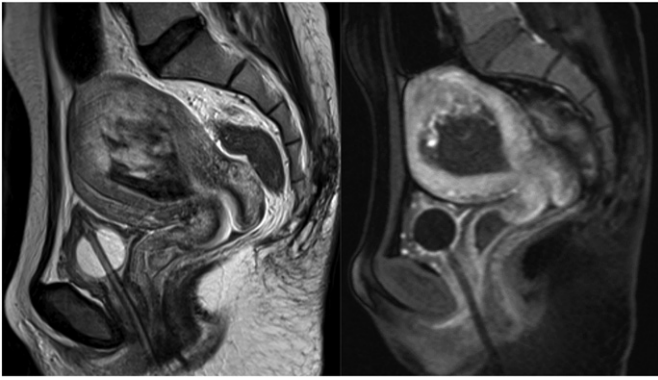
Pelvic magnetic resonance imaging revealed well-enhanced tumor in the uterine fundus. (lt.; T2-weighted sagittal image, rt.; T1-weighted contrast enhanced image).
